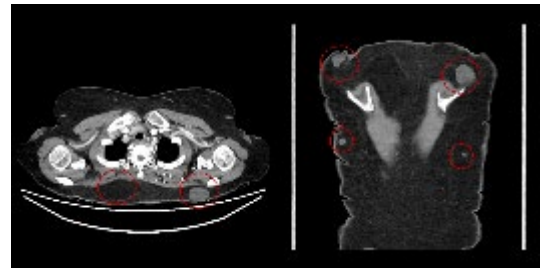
Preoperative computed tomography image demonstrating multiple subcutaneous masses along the posterior trunk. (Dotted line outlines indicate masses)
